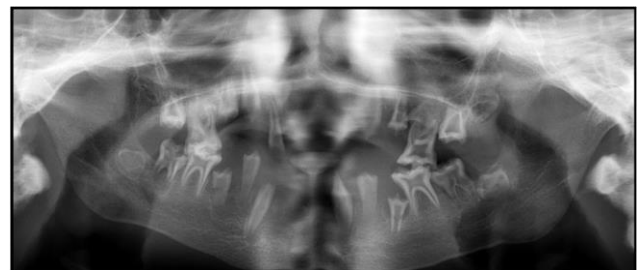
Orthopantomograph showing oligodontia and dysplastic enamel and dentin.
